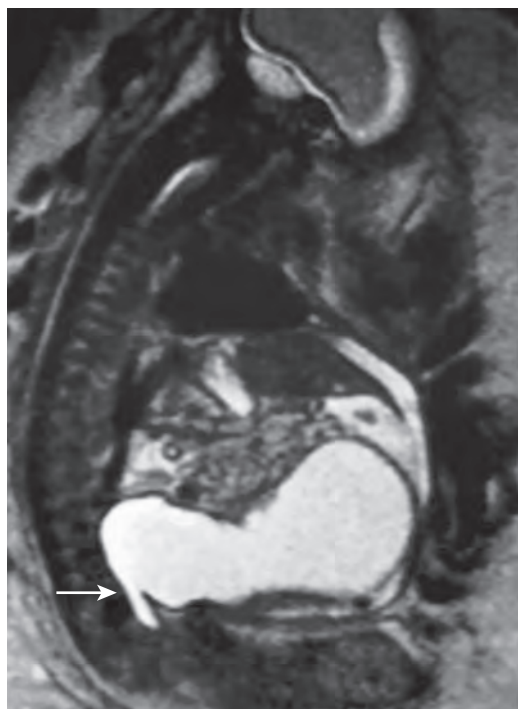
Fetal magnetic resonance imaging demonstrating lower urinary tract obstruction that was postnatally diagnosed as posterior urethral valves. A dilated bladder funneling to a visible posterior urethra (arrow) is seen on this T2 image.
